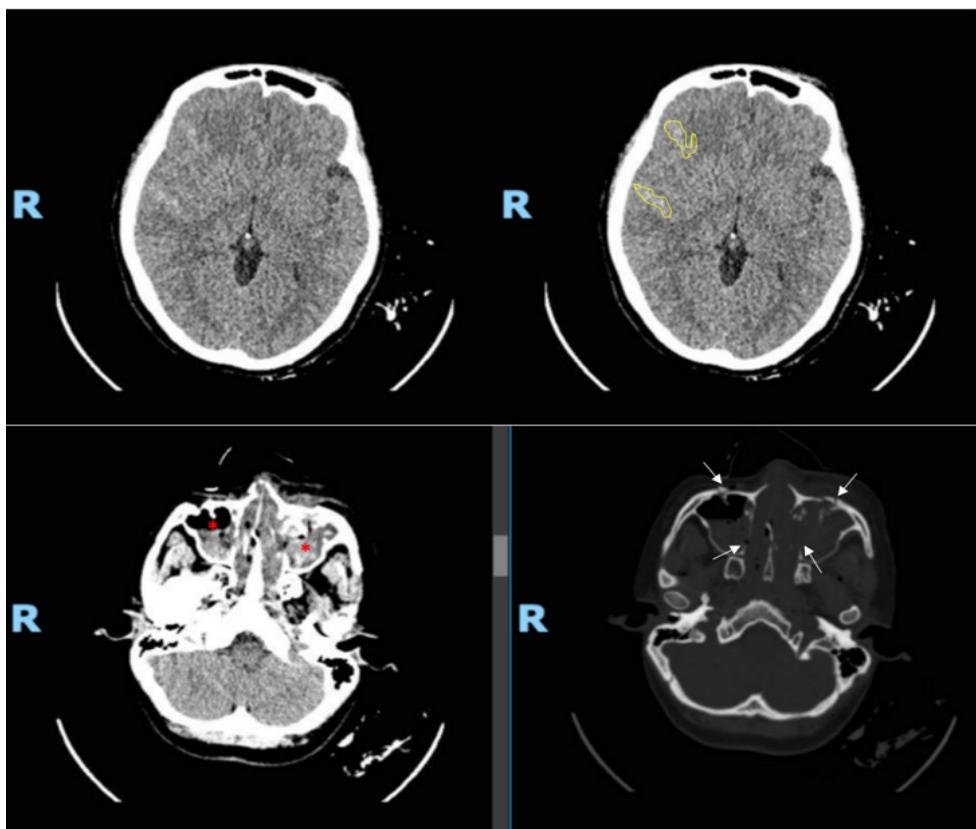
Previous head CT-scan after motor vehicle accident. Top image: right frontotemporal subarachnoid hemorrhage (yellow area); Bottom image: basilar skull fracture and maxillofacial injury (white arrow) with haemato-sinus maxillaries (red asterisk).
